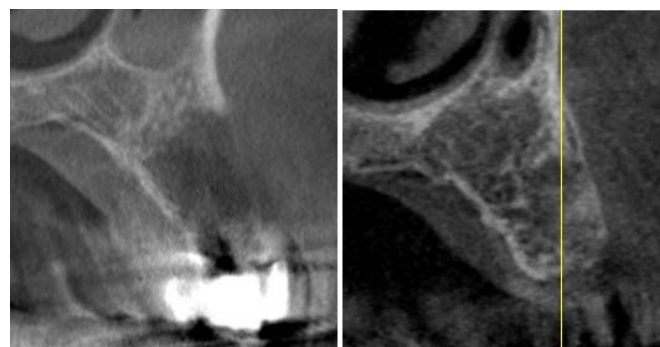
Computed tomography data, cross-section of the alveolar process of the upper jaw. Patient M., 4 months after tooth extraction and microfiber bone grafting in combination with CenoBone™ biogel. A – the state of the socket of the extracted tooth before the operation, B – restoration of bone tissue 5 months after the operation.
